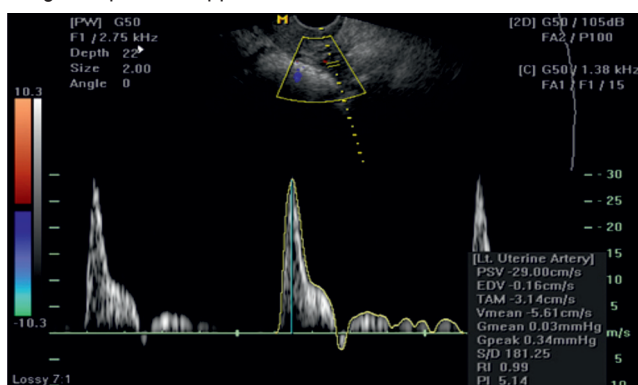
Spectral Doppler in Subfertile Female with reverse diastolic component
